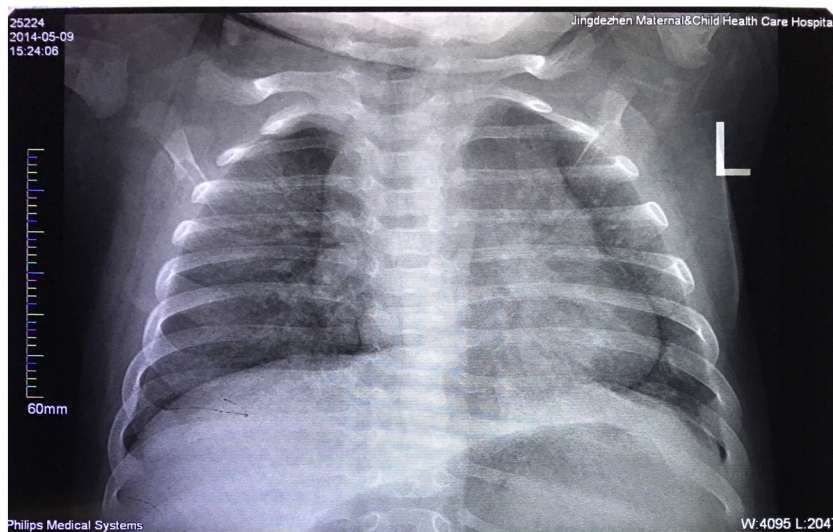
A. Chest X-ray before the treatment. B. After chelated treatment.
